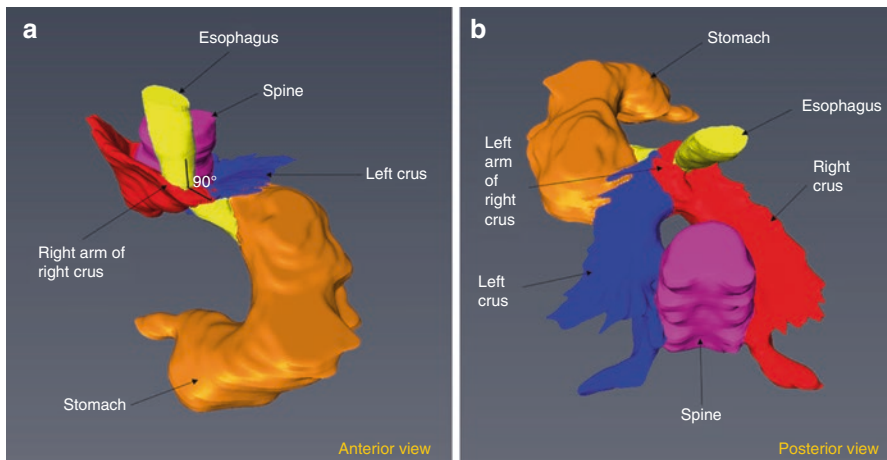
CT scan images of the anterior (a) and posterior views (b) of the EG junction. The esophagus is colored (yellow), the stomach (beige), right crural diaphragm (red), and the left (blue). Note that the esophageal hiatus is mainly formed by the right crus of the diaphragm dividing into two bundles, which surround the esophagus with its left bundle joining the left crus to enforce the esophagus on the left side. Also, note the upper edges of the LES and CD are located where the esophagus makes a sharp turn to the left as it enters the abdomen from the thorax, and the crus is placed at a right angle to the esophagus. (With permission from Mittal et al. [112])
